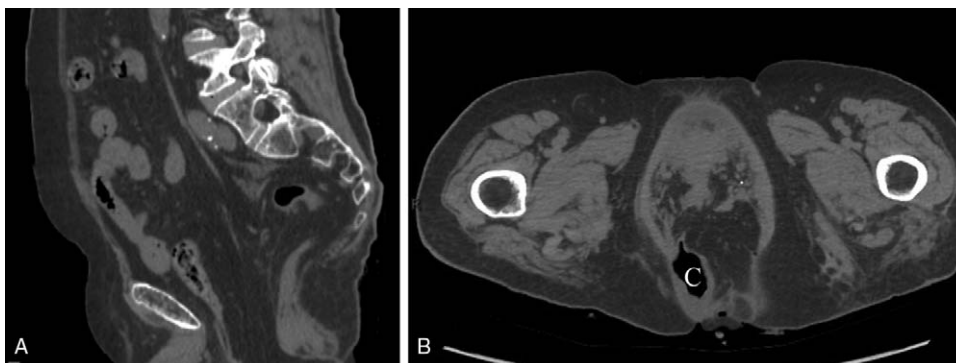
A, Sagittal CT scan image of the abdomen and pelvis shows that the uterus and bladder are absent. B, Transverse CT scan through the upper thighs showing externally herniated the mass. C=Colon, CT= computed tomography.
